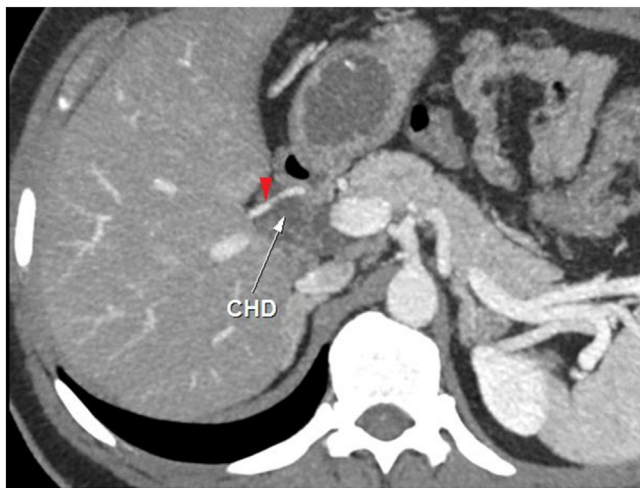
CT Angiography: Axial cross-section showing RHA (red arrowhead) crossing the CHD anteriorly.
